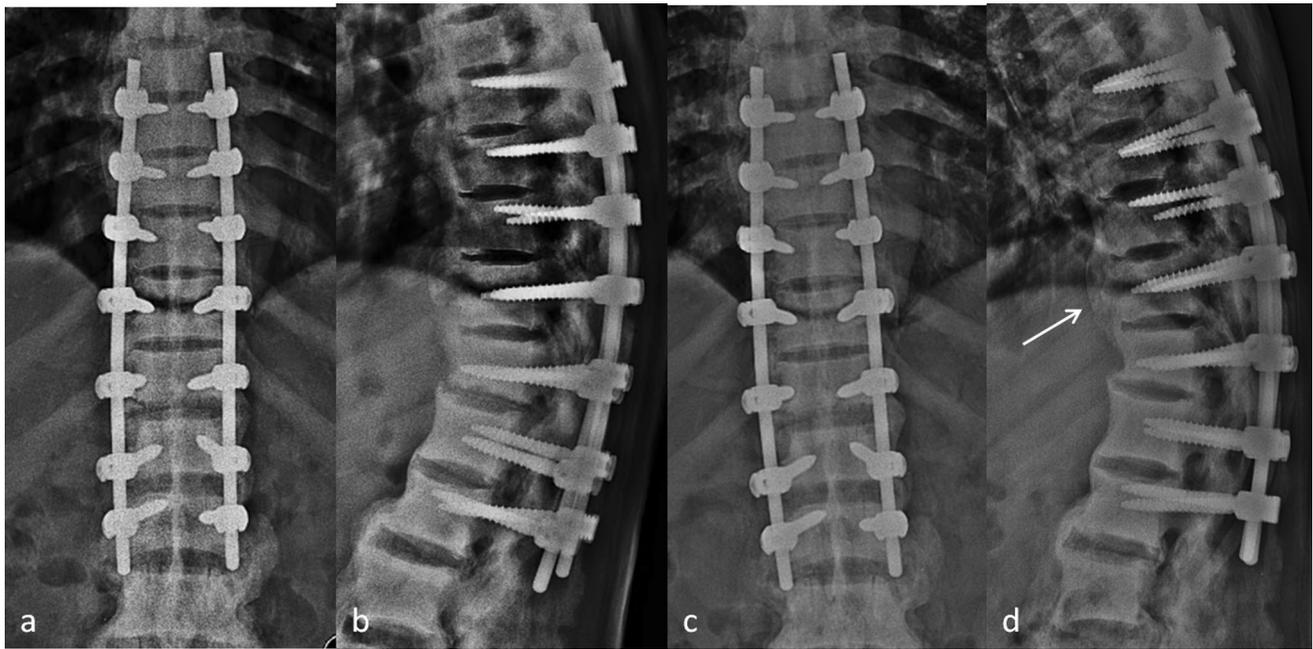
Postoperative radiograph after revision surgery. a, b Immediate post-operative radiograph after extension of fixation. c, d Final follow-up radiograph showing fracture union (*arrow*)
